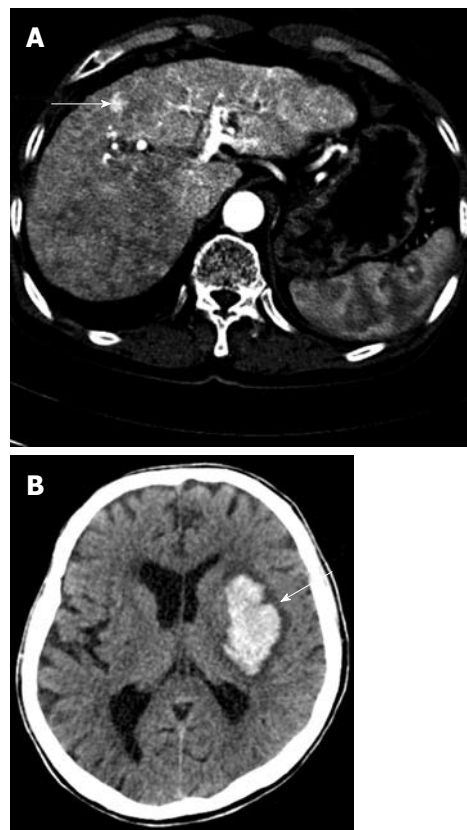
Hepatic arterio-venous shunt and cerebral hemorrhage. A: Abdominal computed tomography (CT) showing an intra-hepatic arterio-venous shunt; B: Cerebral hemorrhage was noted in the left basal ganglia on brain CT.
